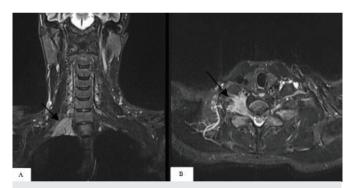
Brachial plexus magnetic resonance imaging neurography with gadolinium, short-tau inversion recovery sequence sagittal (A) and axial (B) images showing pathologic enhancement in the right brachial plexus (black arrows)
